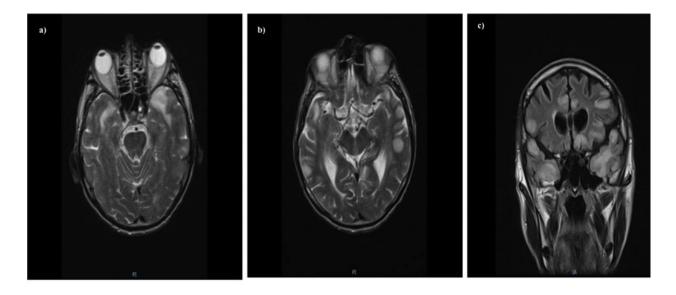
Progression in brain MRI abnormalities. T2 (a,b) and FLAIR (c) MRI imaging showed a more prominent non enhancing gray and white matter involvement.
